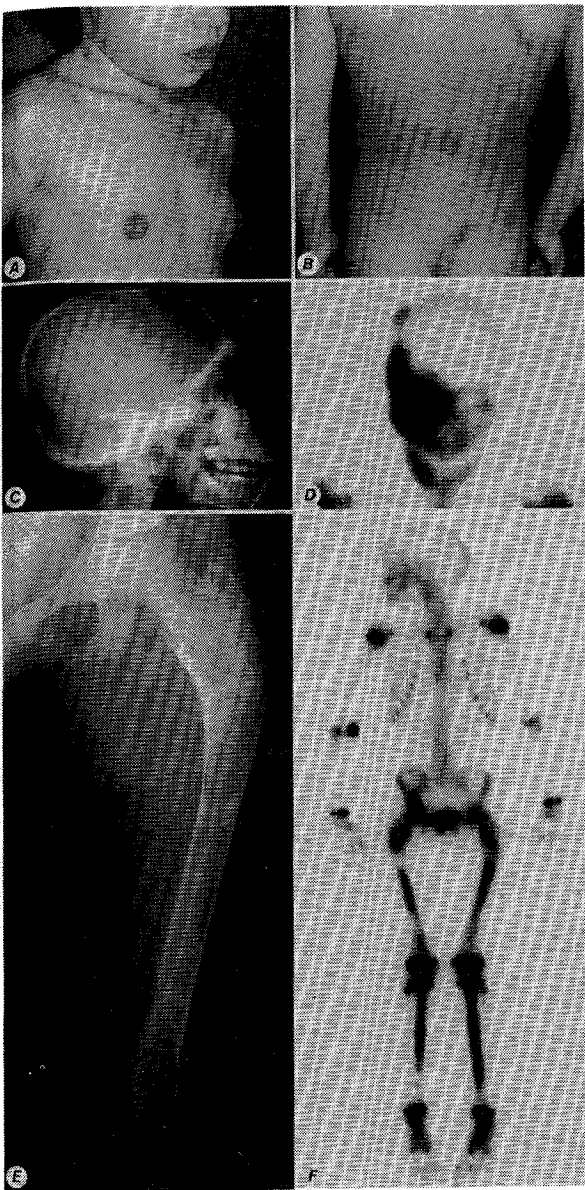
A. Pubertal breast development with enlarged darkened areolas and protruding nipples. B. The typical irregularly shaped café-au-lait skin spots. C. Radiological features of skull bone dysplasia: diffuse skull basis sclerosis. D. Scintigraphic features of skull bone dysplasia: polyostotic lesion of right parietal, zygomatic and maxillary bones. E. Radiologic features of femur bone dysplasia: diffuse osteolytic lesions, fracture and bowing of femoral neck. F. Total body scintigraphic features: high uptake in the pelvis and lower limbs.
